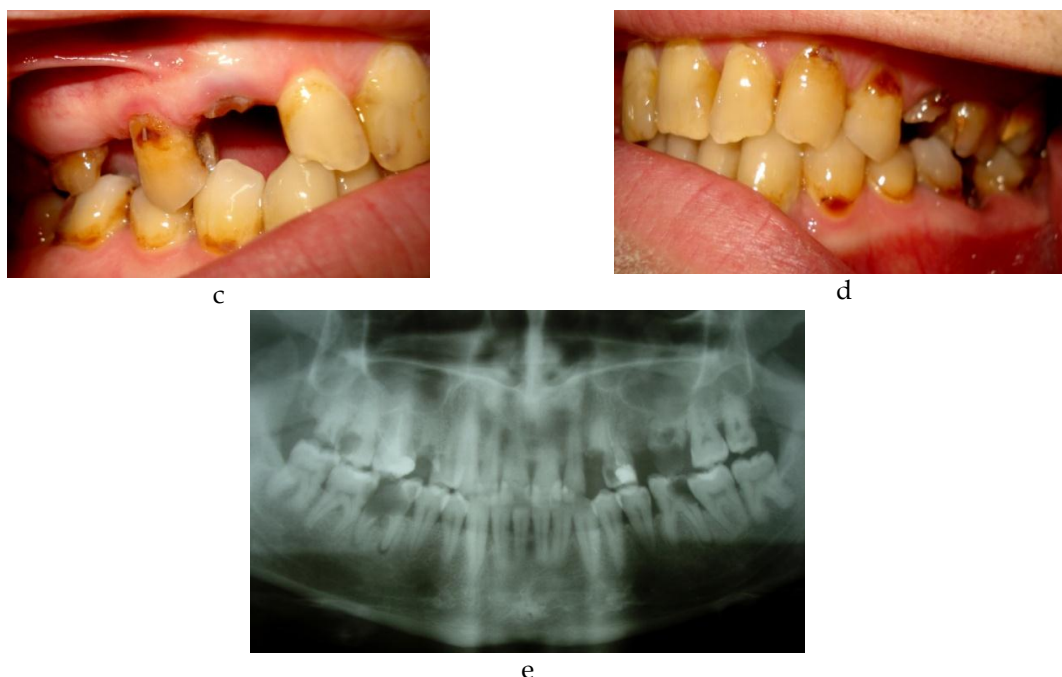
a. presence of dental caries, of massive coronary destructions; b. poor oral hygiene; c, d. presence of demineralization injuries localized at the cervical level of the teeth; e. initial X-ray that shows the presence of multiple irrecoverable dental roots and of periapical reactions
